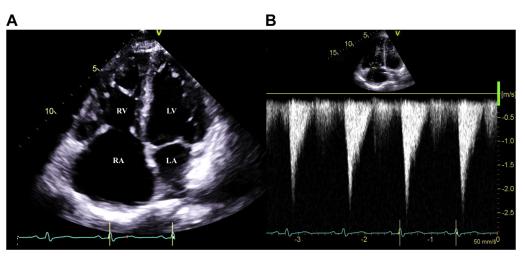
Two-dimensional TTE oriented in an apical four-chamber view showing fixed, semiopen tricuspid valve leaflets during systole (A). Continuous-wave Doppler echocardiogram showing dense, triangular envelope of TR (B).
